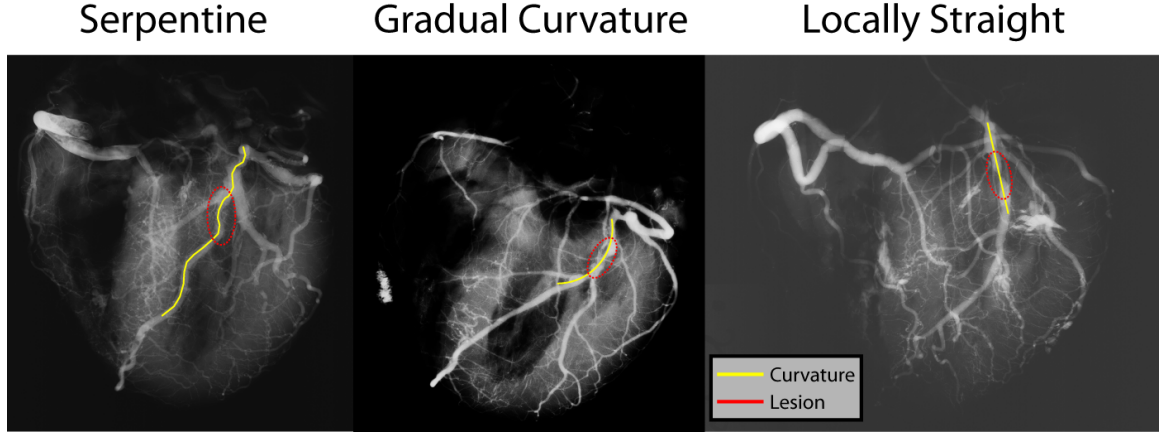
Identification of local curvature: For each lesion identified in x-ray angiograms, we tallied whether the local region was serpentine (left), gradually curving (middle), or locally straight (right).
